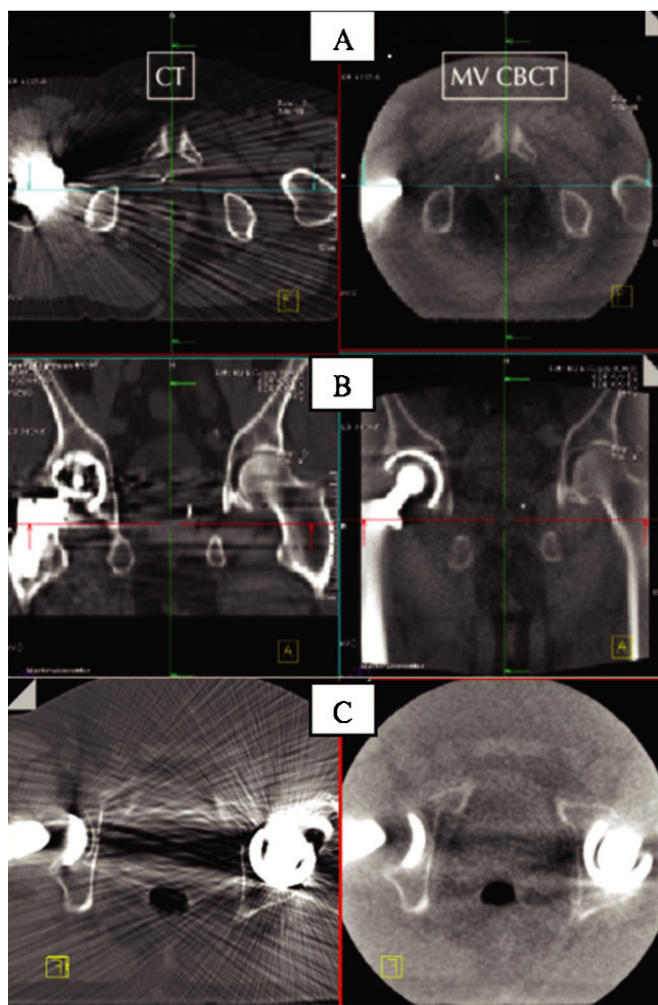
Comparison of a conventional CT (left) and megavoltage cone beam CT (MV CBCT) (right). (A) Axial and (B) coronal views are shown for a unilateral hip replacement. (C) Axial view for a bilateral hip replacement.
